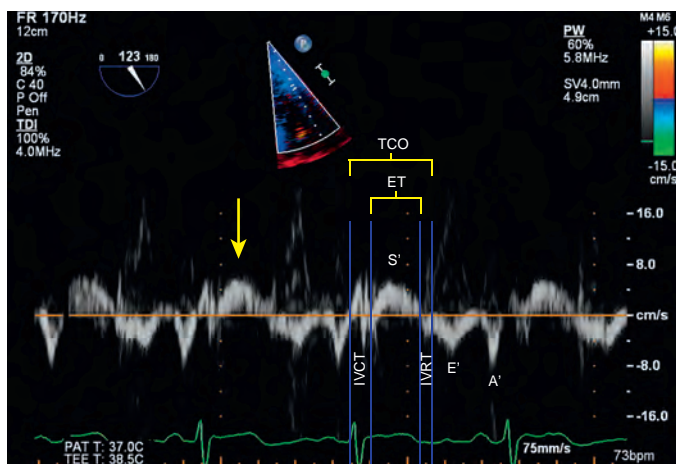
Pulsed-wave tissue Doppler imaging of the lateral tricuspid valve annulus in a modified transgastric right ventricular inflow view. The yellow arrow marks the maximum (peak) tissue velocity (S'). A peak velocity less than 9.5 cm/sec indicates right ventricular dysfunction. This image also allows the determination of tissue Doppler method of right ventricular myocardial performance index (RIMP), calculated as $(TCO - ET)/ET$. A' , Atrial tricuspid velocity; E' , Early tricuspid diastolic velocity; ET , ejection time; $IVCT$, isovolumic contraction time; $IVRT$, isovolumic relaxation time; S' , peak tricuspid systolic velocity; TCO , tricuspid closure opening time.
